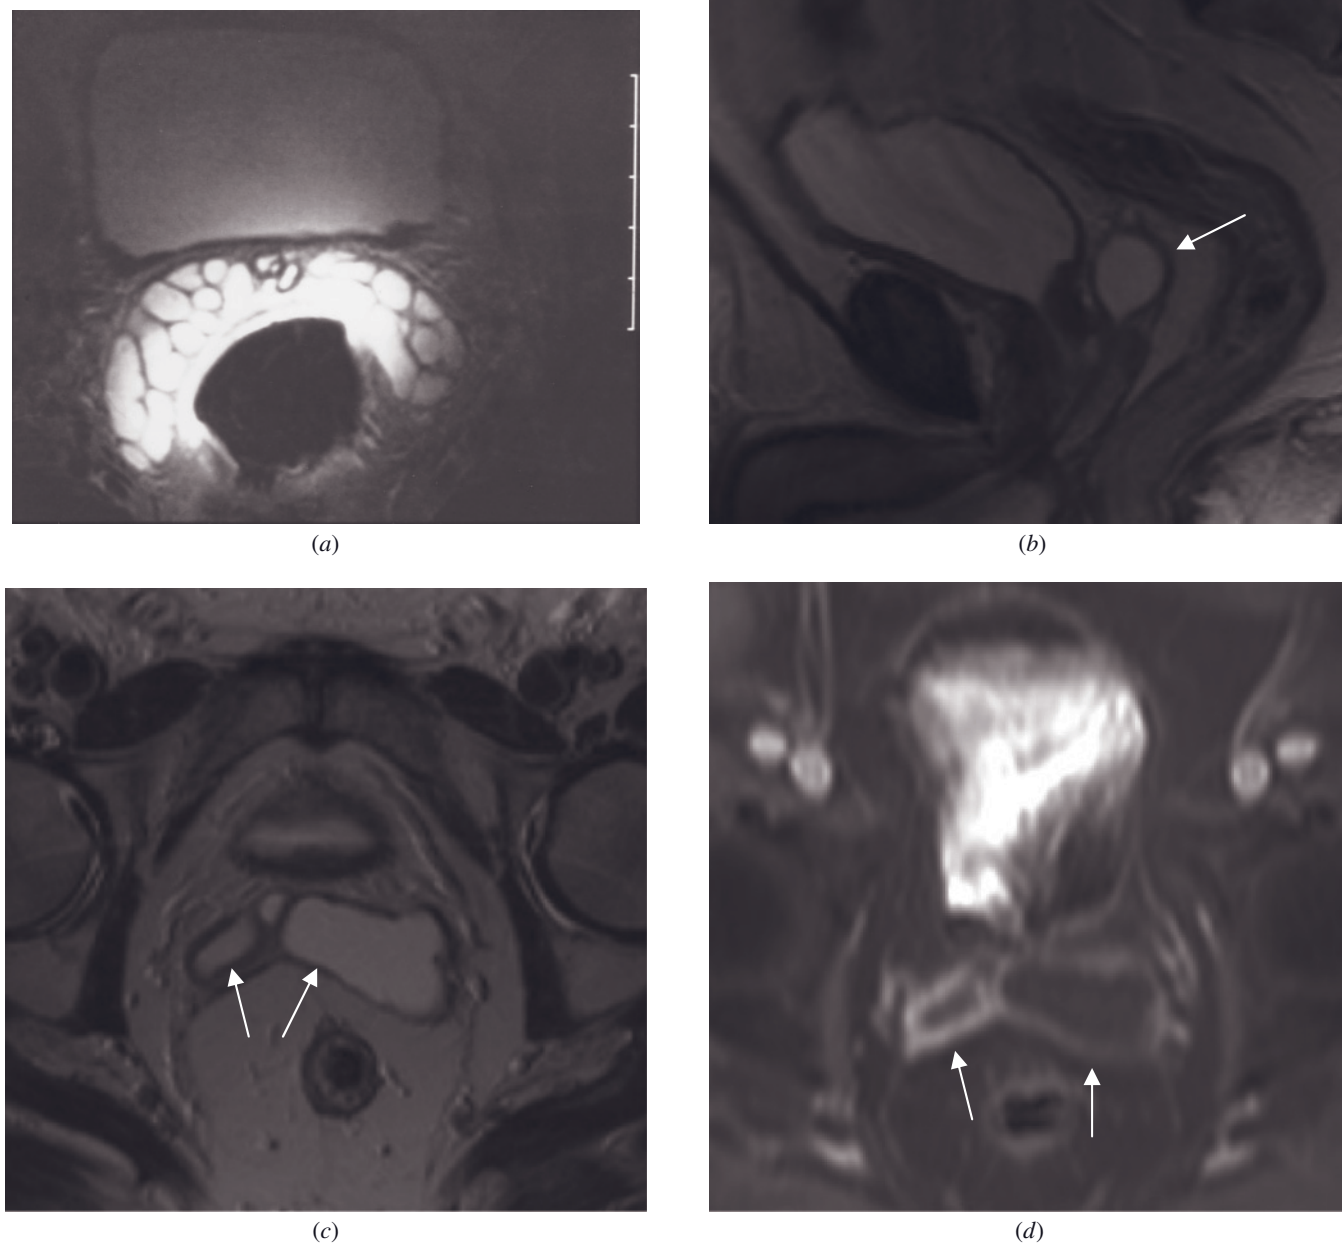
Normal seminal vesicles in the presence of adenocarcinoma of the prostate. Transverse T2-weighted fat-suppressed ETSE endorectal coil image (*a*). Normal, high signal intensity is present within the seminal vesicles in this patient with Stage T2 adenocarcinoma of the prostate. Seminal vesicle cysts. Sagittal (*b*) and transverse (*c*) high-resolution T2-weighted images and T1-weighted postgadolinium fat-suppressed 3D-GE image (*d*) demonstrate bilateral seminal vesicle cysts (arrows, *b-d*) in another patient. The cyst walls show enhancement on postgadolinium image (*d*).
